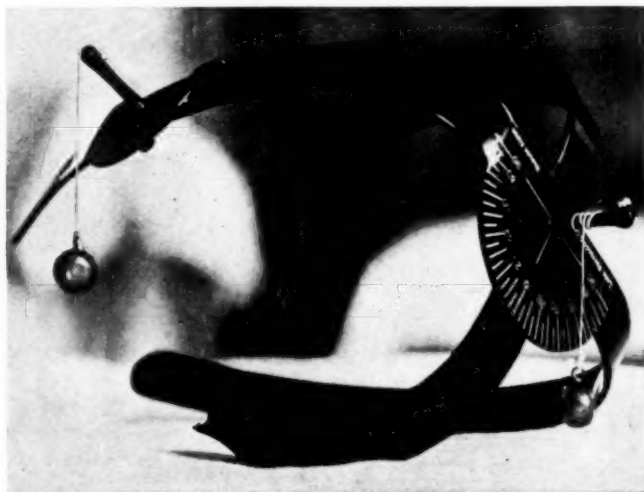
(Argañaraz). Author's device for regulating position of the head in radiography of the optic canal.
